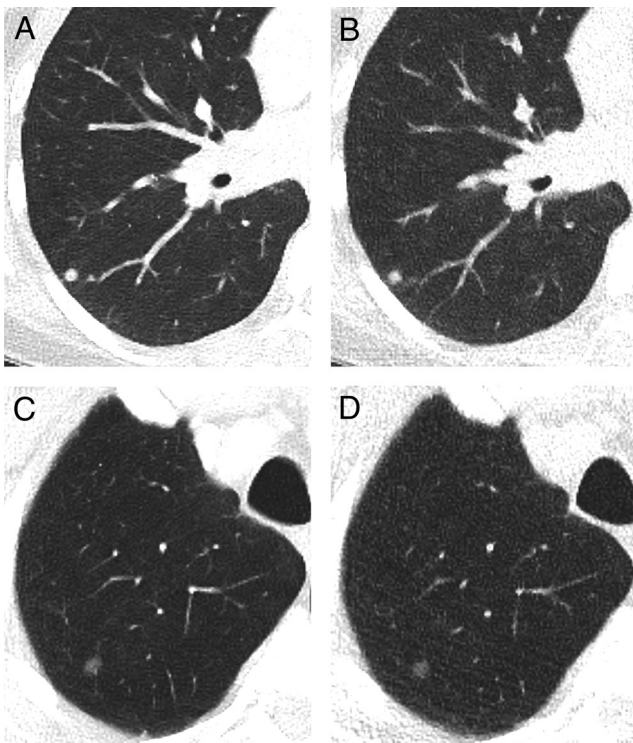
Representative transverse CT sections of the lung in a 33-year-old woman with a body mass index of 23.6 kg/m² scanned with standard dose (A) at 110 kVp and 38 mAs (effective dose, 1.1 mSv; size-specific dose estimate, 3.09 mGy) and ultralow dose (B) at 100 kVp and 70 mAs (effective dose, 0.14 mSv; size-specific dose estimate, 0.37 mGy). The solid pulmonary nodule in the right lower lobe was detected in ultralow dose CT by both readers (i.e., true positive finding). Representative transverse CT sections of the lung in a 79-year-old man with a body mass index of 24.9 kg/m² scanned with standard dose (C) at 100 kVp and 62 mAs (effective dose, 1.33 mSv; size-specific dose estimate, 3.1 mGy) and ultralow dose (D) at 100 kVp and 70 mAs (effective dose, 0.13 mSv; size-specific dose estimate, 0.3 mGy). The subsolid pulmonary nodule in the right upper lobe was detected in ultralow dose CT by both readers (i.e. true positive finding)
